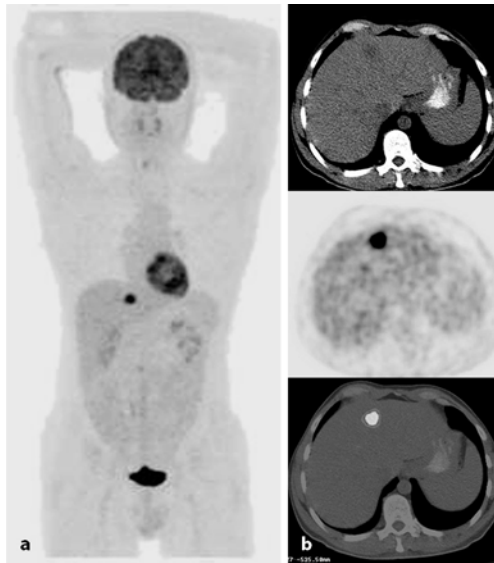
a, b. A 37-year-old male patient with a history of two meta-chronous colon carcinomas (ascending colon, sigmoid) operated 3 weeks earlier with a suspicious lesion in the liver. FDG-PET-CT reveals focal FDG-uptake in a hypodense lesion in the liver, localized in the left liver (segment 2) with pathological FDG-uptake (b; axial image). Otherwise unremarkable PET/CT study
